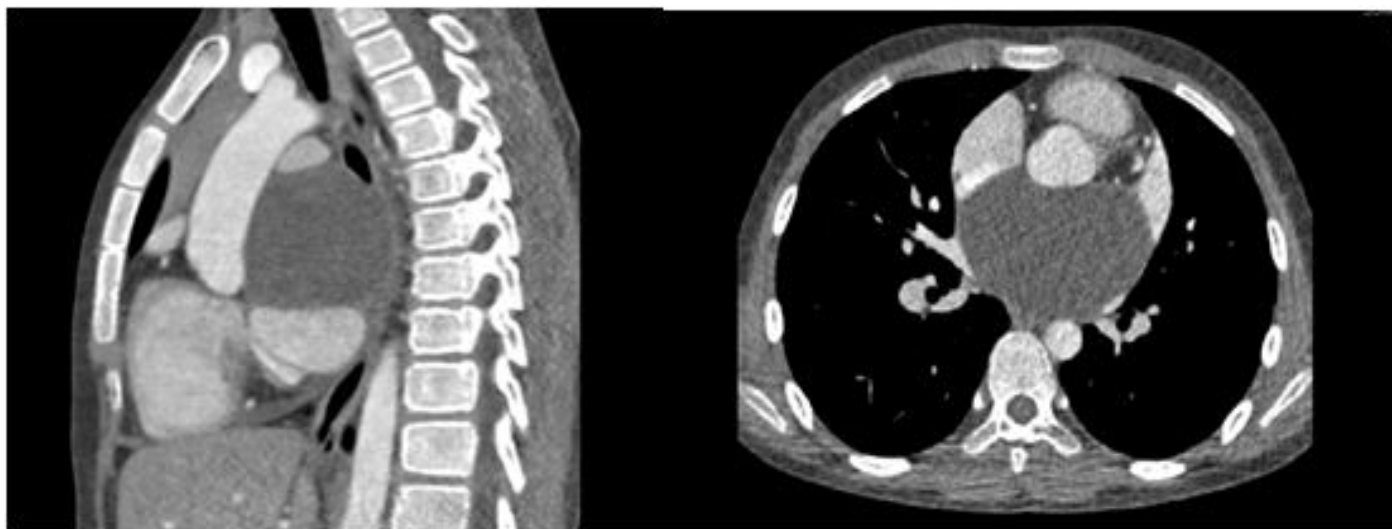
Pericardial cyst in cardiac CTA.
